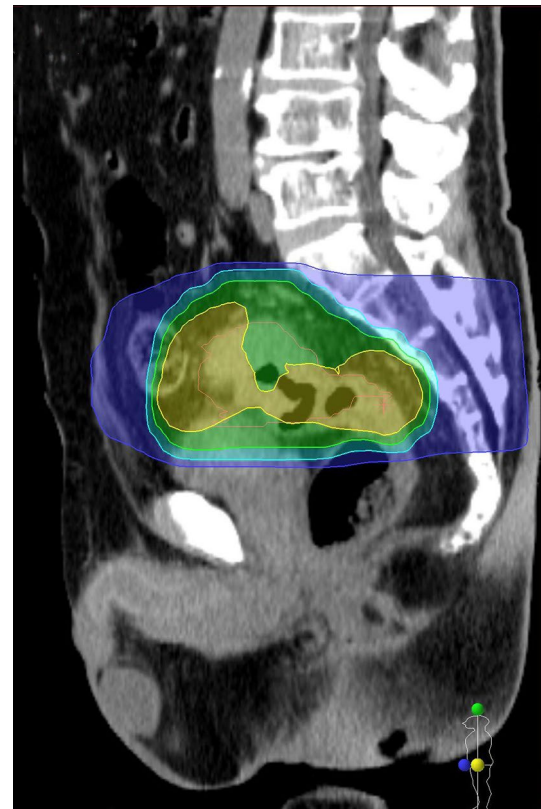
Sagittal image of abdominal computed tomography before re-irradiation to the rectal cancer
